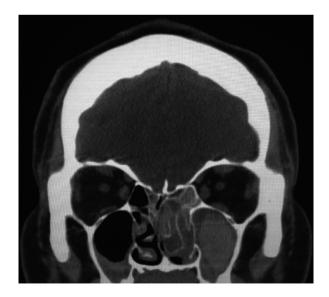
Coronal non-contrast CT scan showing the "double densities" characteristic of AFS
